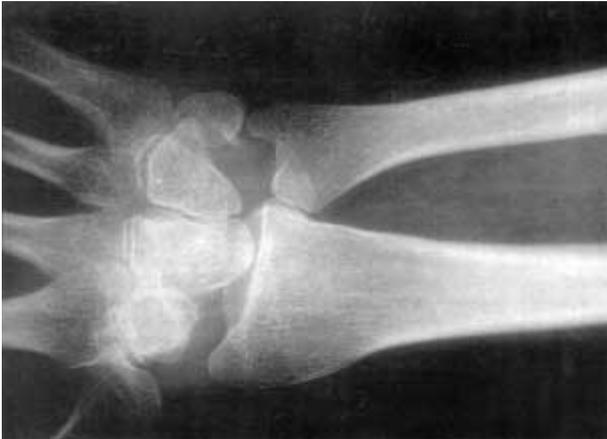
Postoperative xray of the wrist
